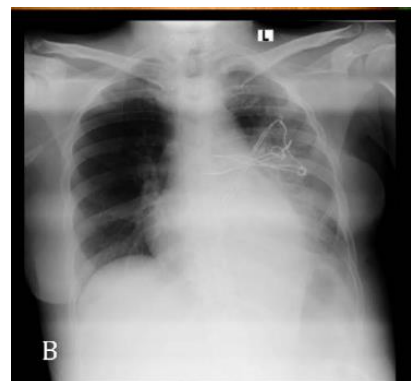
(A) Intraoperative view of the surgical mesh (B) Postoperative X-ray demonstrating sternal wires.
